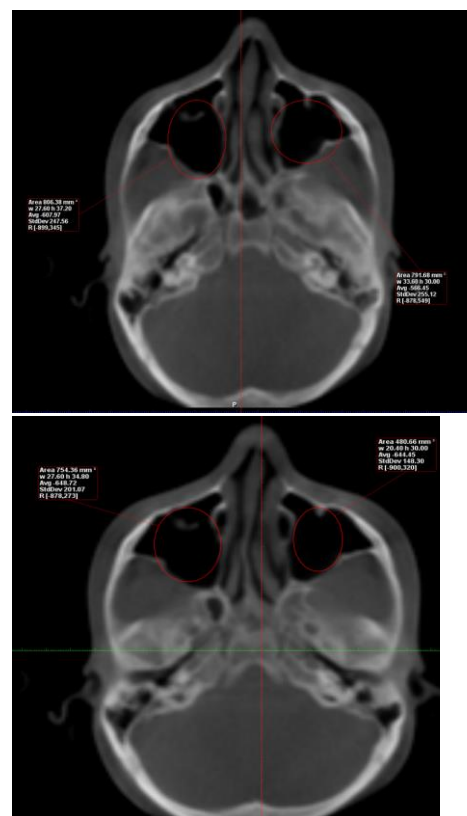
shows the Width and height of a male cbct
